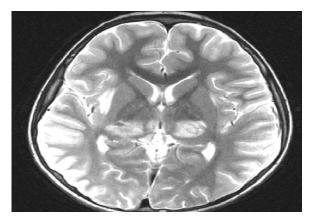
Axial T2-weighted image shows symmetric increased signal intensity in the thalami.
